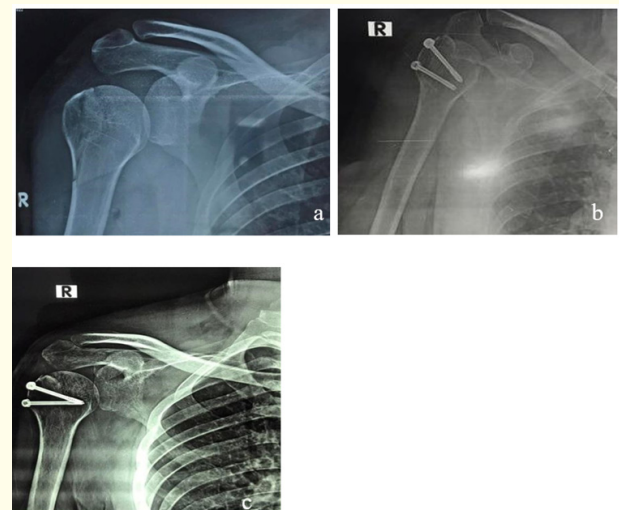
A 41-year-old male porter presenting after a fall on right hand with hyper abduction of the right shoulder, plain x-ray AP shows greater tuberosity un-displaced fracture (a) at presentation and (b) after 3 weeks of operation with fixation by 2 cannulated screws (c) with complete healing of the fracture after 4 months.
